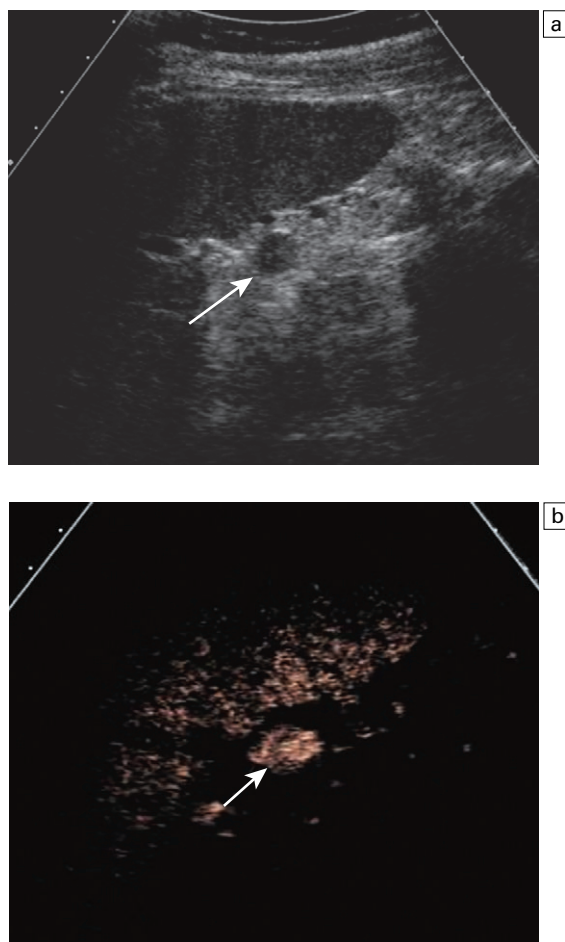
Microbubble contrast enhanced ultrasound demonstrates the parenchymal enhancement of a splenunculi that matches the spleen; (a) baseline image demonstrates a well circumscribed iso reflective (to spleen) area (arrow) adjacent to the splenic hilum; (b) following the administration of Levovist® using ADI®, there is microbubble contrast uptake in the late phase confirming the presence of splenic tissue (arrow).
